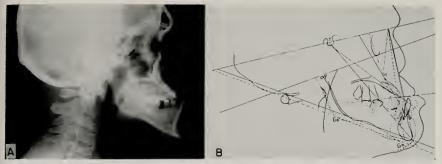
Oriented lateral radiograph of patient shown in figure 3. B. An oriented lateral radiograph is traced and postoperative position is determined. Broken lines indicate new position. Measurements are made from point b.
